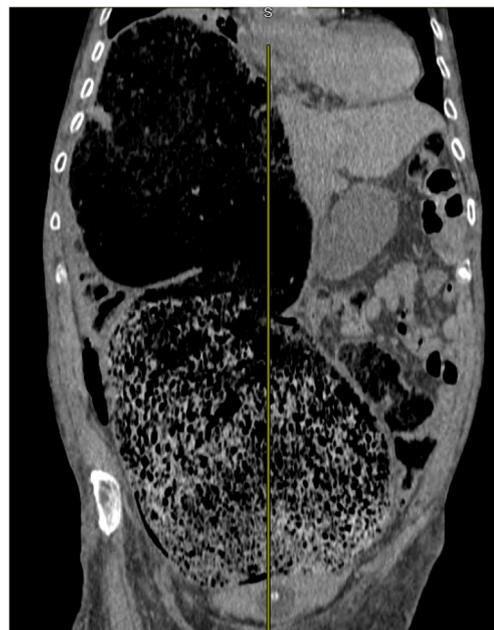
Abdominopelvic CT scan, coronal view, without injection of product contrast: giant fecaloma extending from the lower rectum to the right diaphragmatic region. The liver is repressed medially; the rest of bowel and left colon are flat and compressed. The bladder is compressed, and a catheter solves the chronic retention
